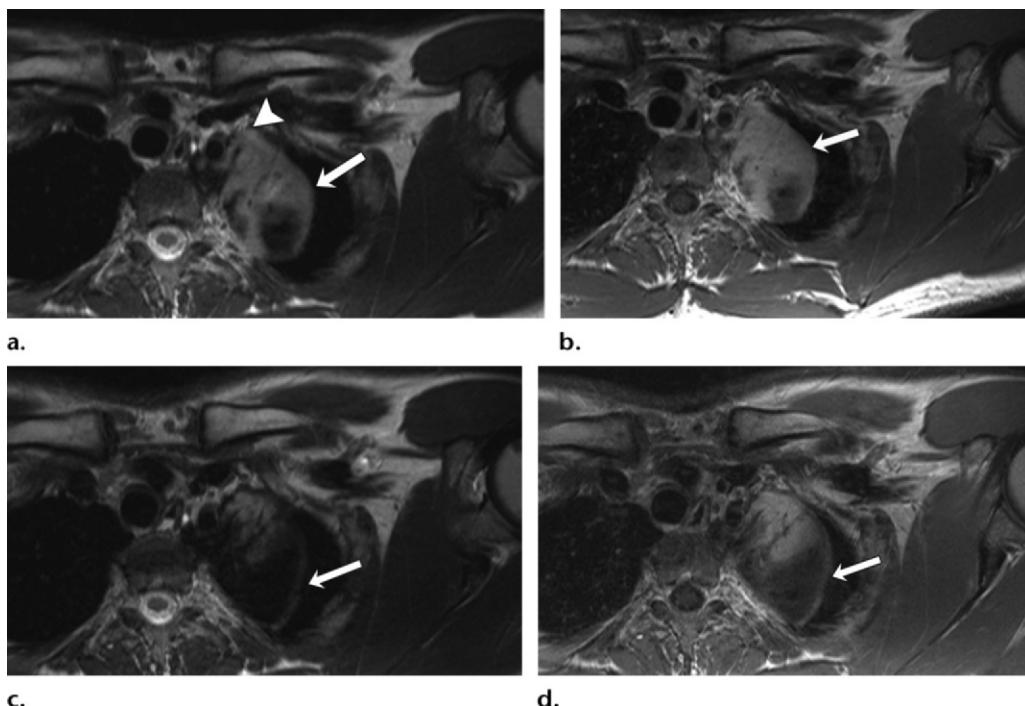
Positive response to systemic therapy with sorafenib of an unresectable extra-abdominal left apical thoracic DF in a 27-year-old man. (a) Axial T2-weighted MR image (8300/63) shows a well-defined heterogeneously hyperintense left apical thoracic mass (arrow) with involvement of the neurovascular bundle (arrowhead). (b) Axial postcontrast T1-weighted MR image (796/11) shows heterogeneous avid enhancement of the mass (arrow). (c, d) Axial T2-weighted (8390/63) (c) and postcontrast T1-weighted (648/12) (d) MR images after 9 months of therapy with sorafenib show a slight interval increase in size, but a marked decrease in signal intensity (arrow in c) and in enhancement (arrow in d), especially the posterior component.
